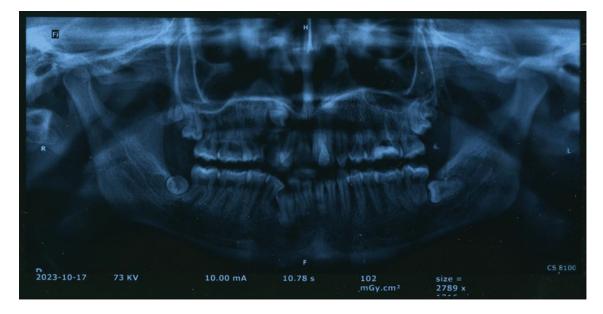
Patient's OPG radiograph. Abbreviation: OPG, orthopantomography.
